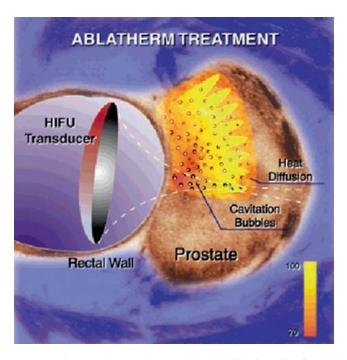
Ultrasound waves generated by the high-intensity focused ultrasound (HIFU) transducer are focused on the tumor lesion within the prostate
